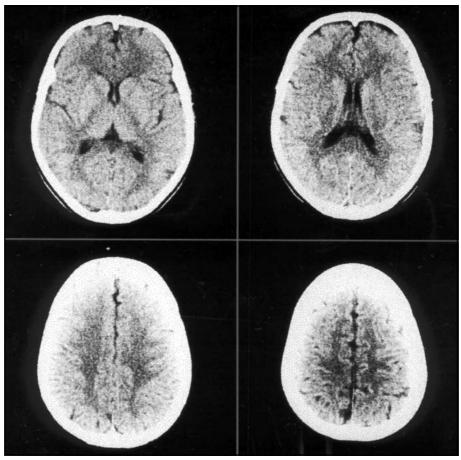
Follow-up brain CT of Patient 2, five months later, shows complete resolution of the previous lesions.
